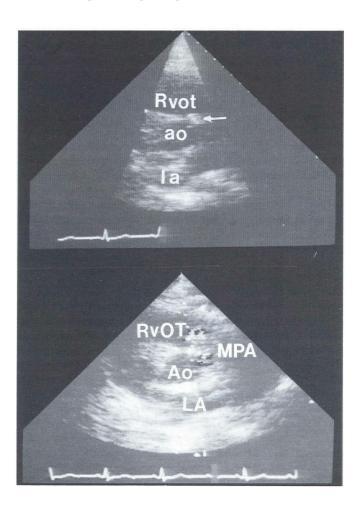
Upper panel: two-dimensional echocardiogram (short axis view) demonstrating pulmonary valve vegetations. Lower panel: color flow Doppler demonstrating mild pulmonic insufficiency (arrow). (AO = aorta, LA = left atrium, MPA = mainpulmonary artery, RVOT = right ventricular outflow tract.
